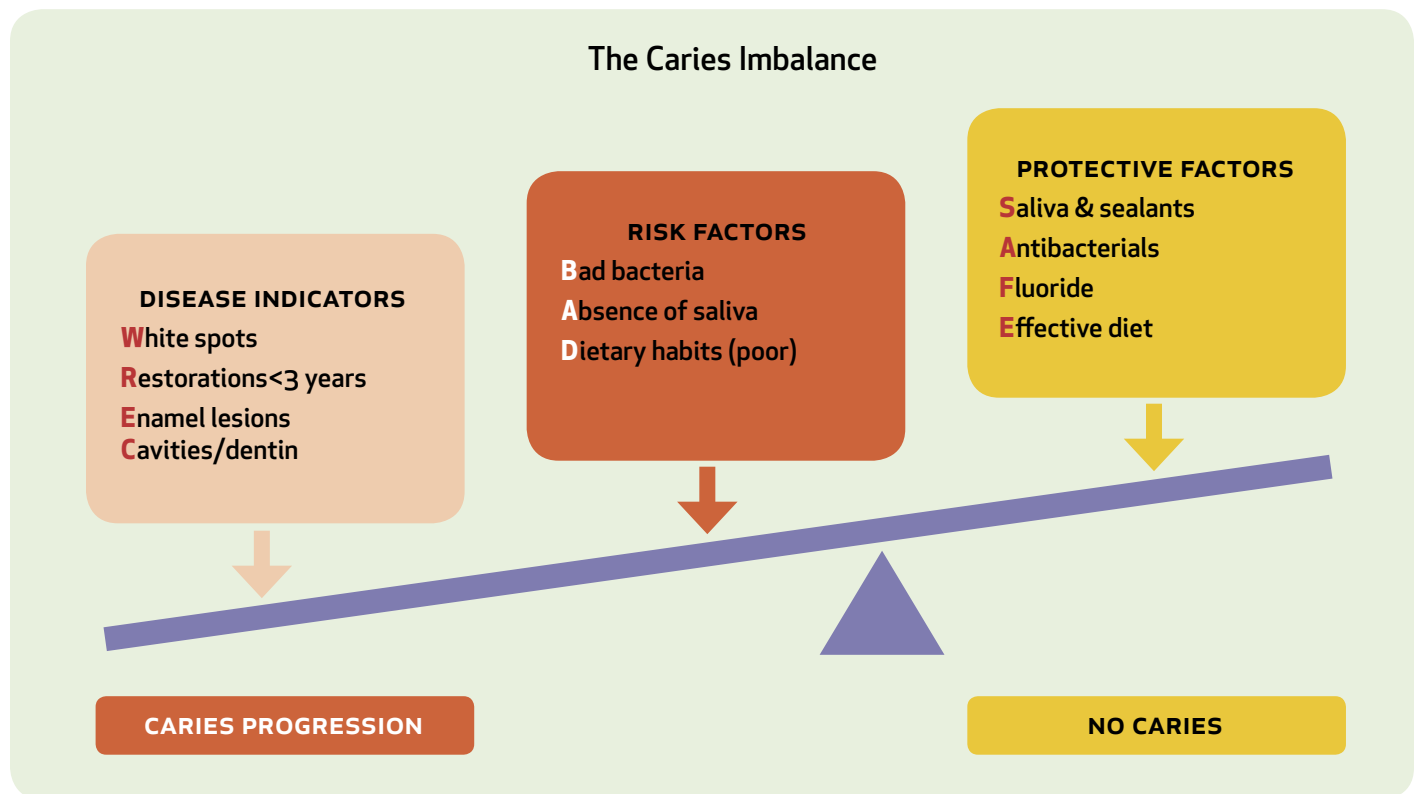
The caries “imbalance.” The balance amongst disease indicators, risk factors and protective factors determines whether dental caries progresses, halts, or reverses. Refer to TABLE 1 and the text for more detail on disease indicators. Cavities/dentin refers to frank cavities or lesions to the dentin by radiograph. Restorations < 3 years means restorations placed in the previous three years. This figure has been updated from previous versions of the “caries balance” with the very important addition of the disease indicators.⁶ If these indicators are present they weigh heavily on the side of predicting caries progression unless therapeutic intervention is carried out. The leading letters that help to remember the imbalance (WREC; BAD; SAFE) have been added, as well as sealants as a protective factor. Dietary habits (poor) indicates frequent ingestion of fermentable carbohydrates (greater than three times daily between meals).
